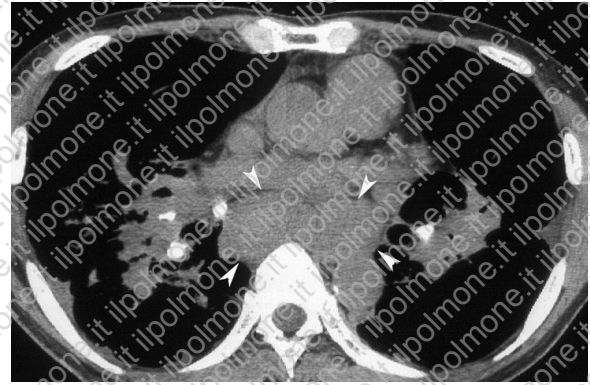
Mediastinal adenopathy in a 60-year-old man. Unenhanced chest CT scan demonstrates calcification in the affected hilar nodes, a finding that suggests a long clinical course. Note the simultaneous presence of huge subcarinal lymph nodes (arrowheads), an unusual finding in other granulomatous diseases such as tuberculosis.
